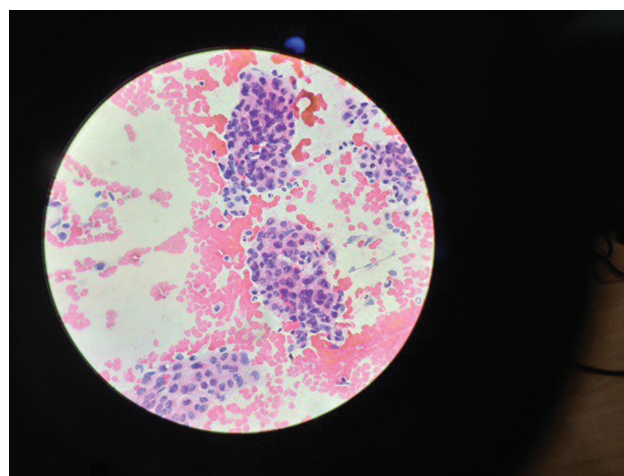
Computed tomography-guided hepatic biopsy suggestive of hepatocellular carcinoma (well-differentiated) with tumor thrombosis.
